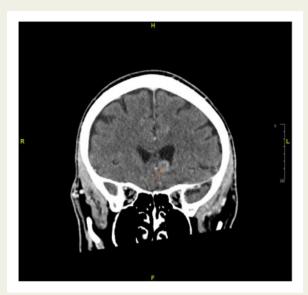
Coronal view of contrast computed tomography head shows an area of high attenuation medial to the left frontal lobe (indicated by red arrow) the appearances are atypical of a haemorrhage, and this may represent a mass or a bleed into a mass. There is no post-enhancement in the mentioned areas of interest. There is a probable small 4-mm aneurysm at the junction of the anterior communicating artery on the left.
